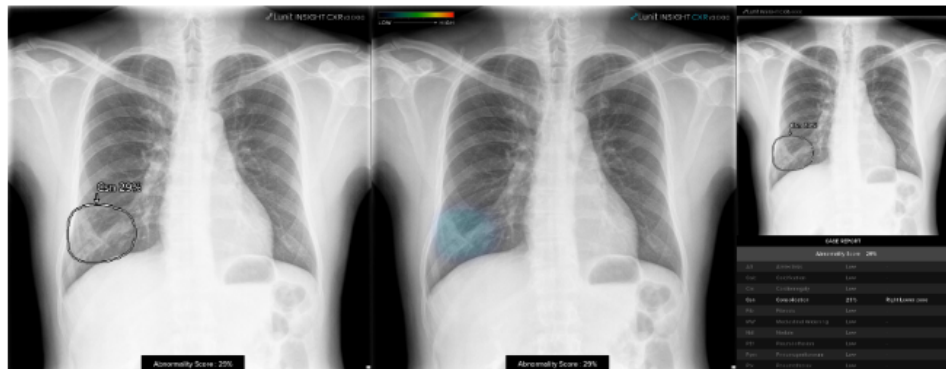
Lunit Insight CXR detects pneumonia in the chest x-ray image
